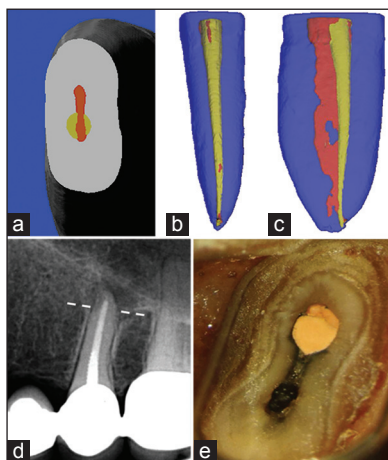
The illusion of evaluating root canal instrumentation and filling by 2D periapical radiographs. (a-c) A long-oval root canal that was instrumented using rotary files. Red: Before; yellow: After. (a) A cross-section, 5 mm from the apex. Note the round preparation and the un-instrumented “fin”. (b) Buccal view of the same root canal: This preparation, when obturated, is likely to produce a nice periapical radiograph. (c) Mesial view of the same root revealing the extent of the un-instrumented “fin”. (d and e) A clinical case (courtesy of Dr. Amir Weisman, Tel Aviv). (d) Left maxillary second premolar with apparently adequate preparation and obturation. The case failed clinically. Apical surgery (sectioning along the dotted line) revealed the reason for failure
